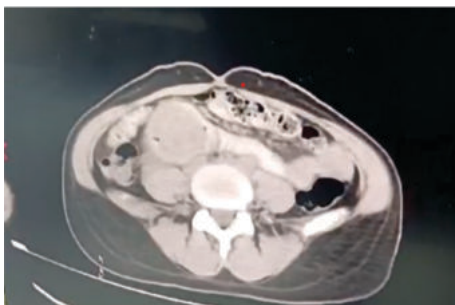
CT Image Showing Duodenal Mass Causing Intussusception And Target Sign
